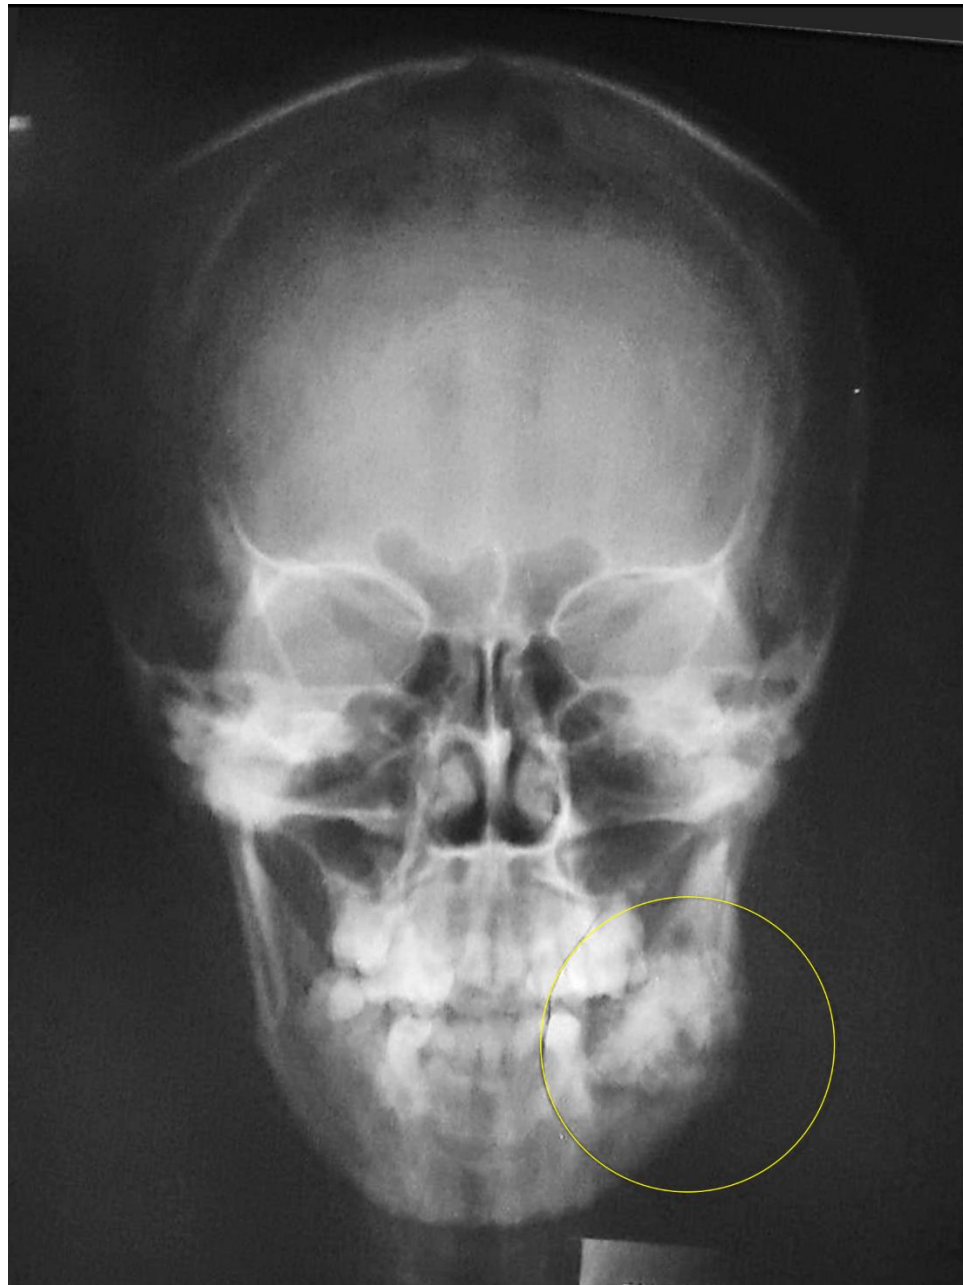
Posteroanterior cephalometric radiograph shows lateral expansion of the lesion causes mandibular asymmetry
